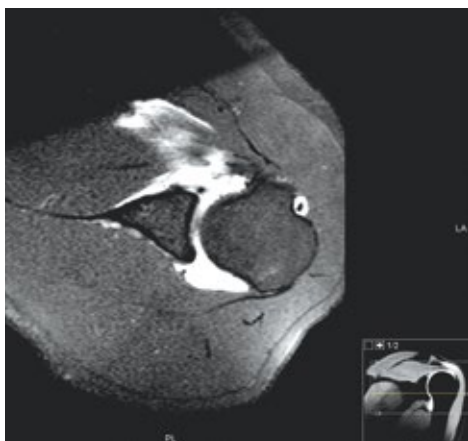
Example of a joint capsule lesion (arrow) (axial orientation, T1-weighted): stripping of the anterior capsulo-ligamentous complex from the anterior rim of the glenoid
